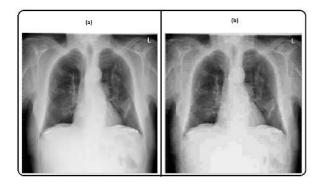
(a) The original watermarked X-Ray image, (b) The image after 10% JEPG compression attack
